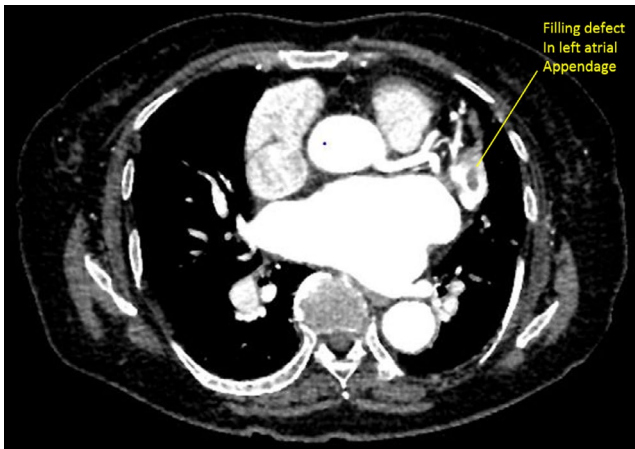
Contrast-enhanced computed tomography revealed a filling defect in the left atrial appendage (LAA) that was diagnosed as a thrombus. Arrowhead: The filling defect
